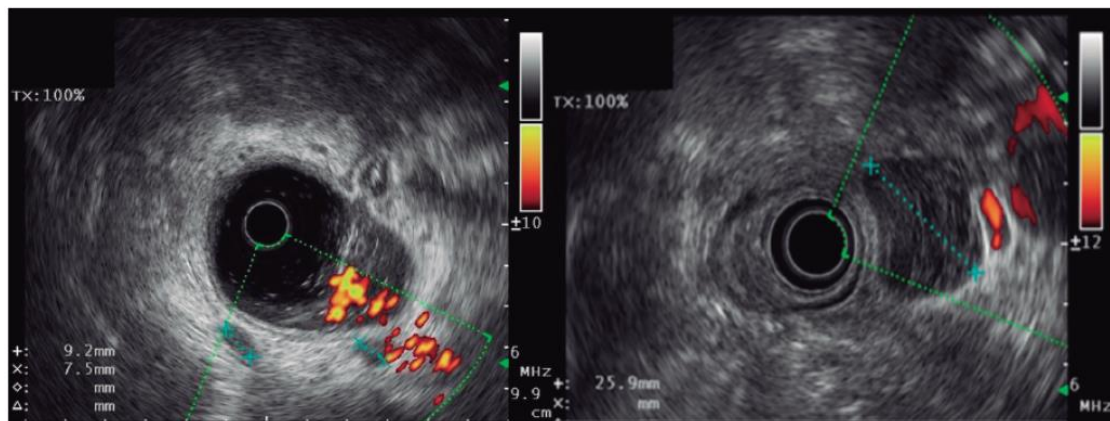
Endoscopic ultrasound assessment of regional adenopathies in rectal tumors.
